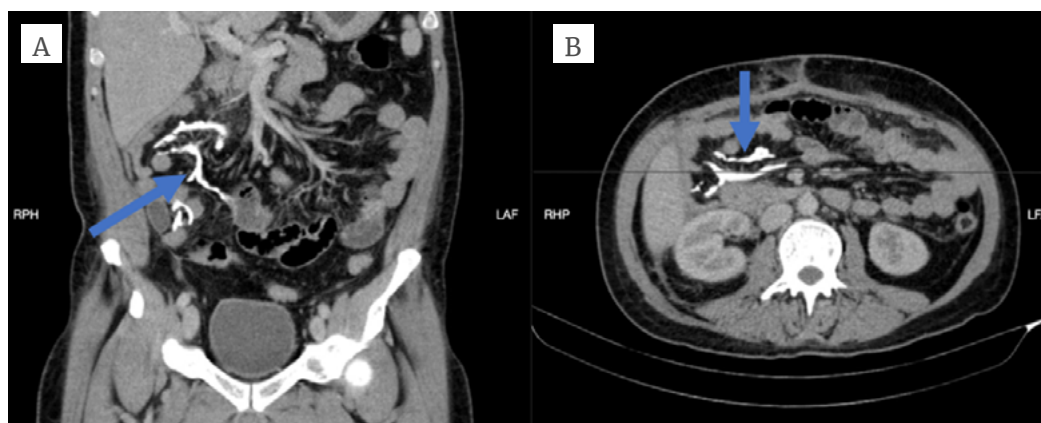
Contrast-enhanced computed tomography of the abdomen showing a hyperdense image suggestive of bone tissue in the mesentery. A) coronal view: the arrow points to a hyperdense image at the root of the mesentery, suggestive of bone formation; B) axial view: the arrow points to evidence of hyperdense foreign body suggestive of bone.
